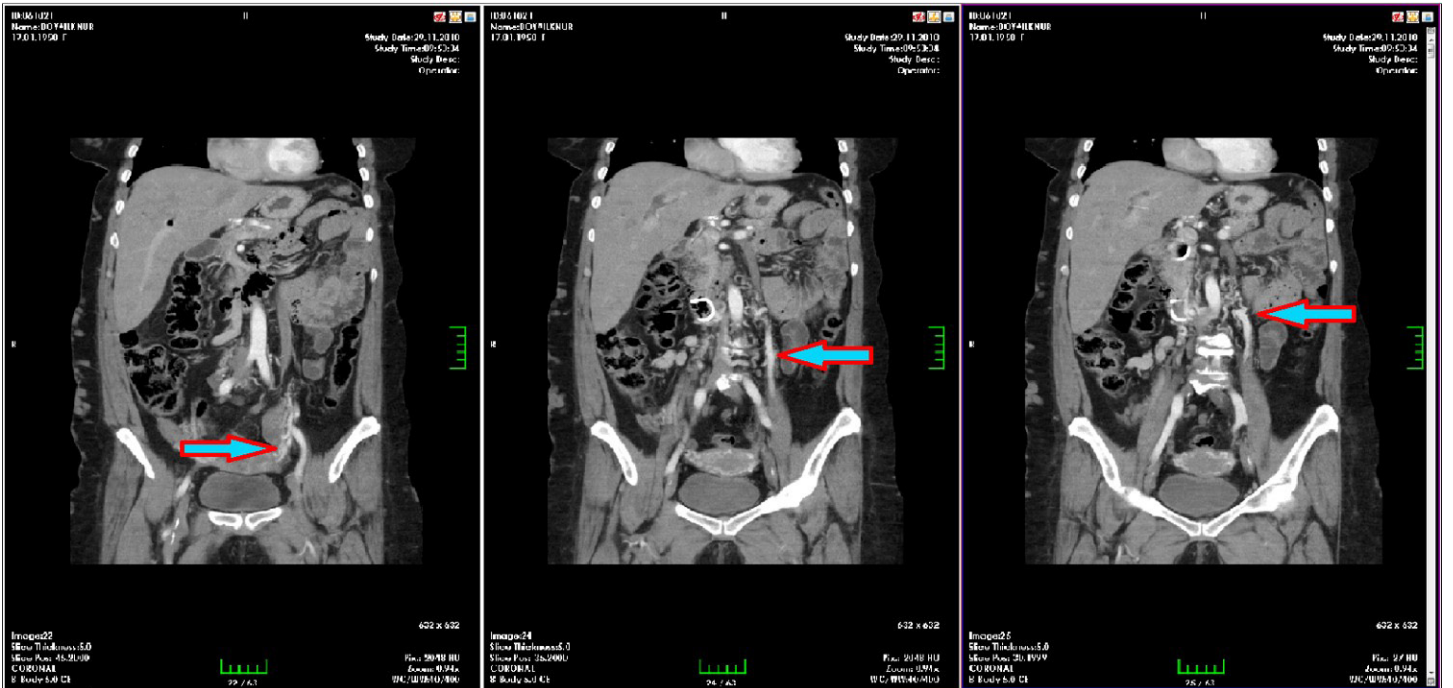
In Contrast CT Sections; Secondary to infra-renal IVC agenesis, tortuous left ovarian vein, showing ectatic dilatation by increasing calibration to provide venous system drainage, and pouring into the left renal vein.
